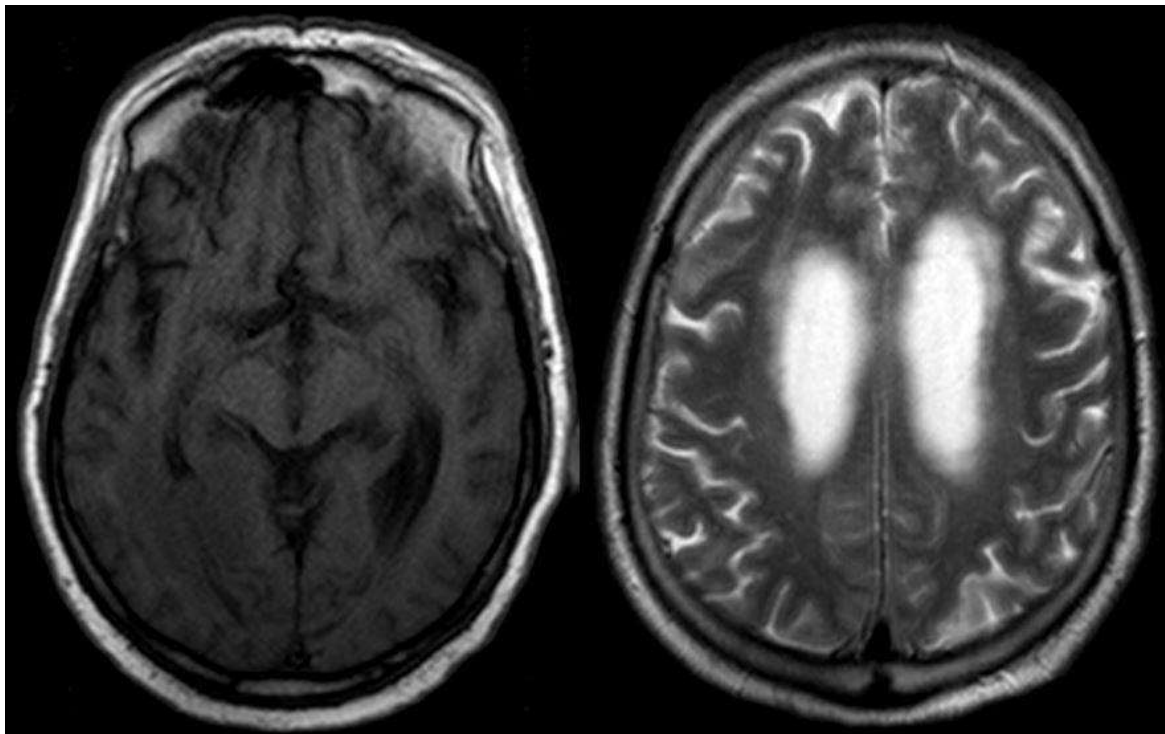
Brain MRI image at follow-up examination.
